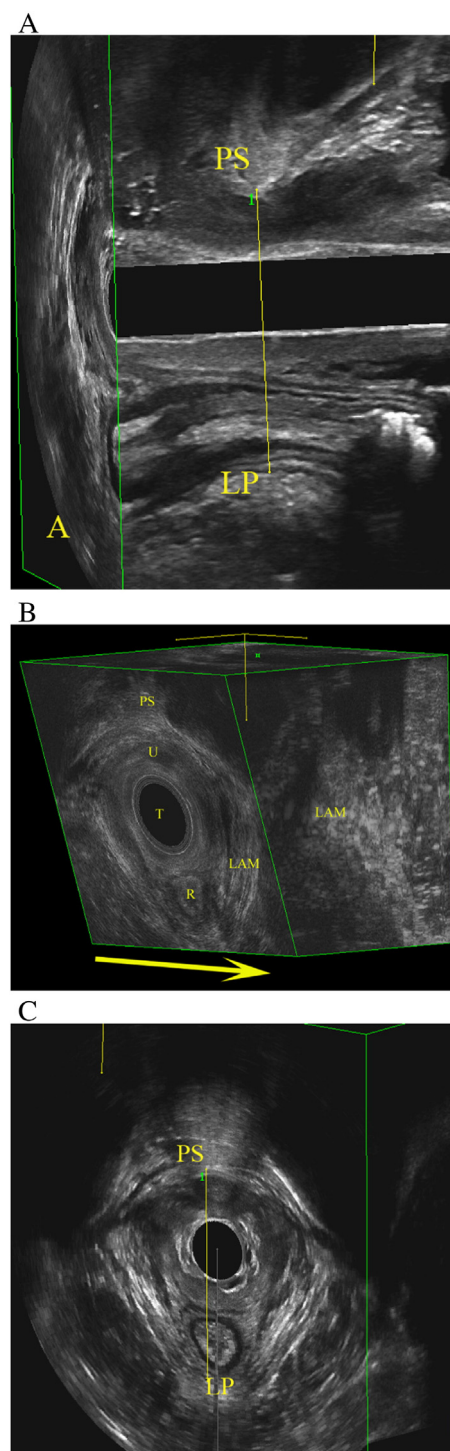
Three-dimensional ultrasonography of the minimal levator hiatus area. (A) Midsagittal view used to determine the shortest distance between the pubic symphysis and the levator plate. (B) Manipulation of the volume in midsagittal view to have access to the axial view of the minimal levator hiatus. The arrow indicates the direction of manipulation. (C) Axial view of the shortest distance between the pubic symphysis and the levator plate. Abbreviations: PS, pubic symphysis; LP, levator plate; U, urethra; T, transducer; R, rectum; LAM, levator ani muscle.
